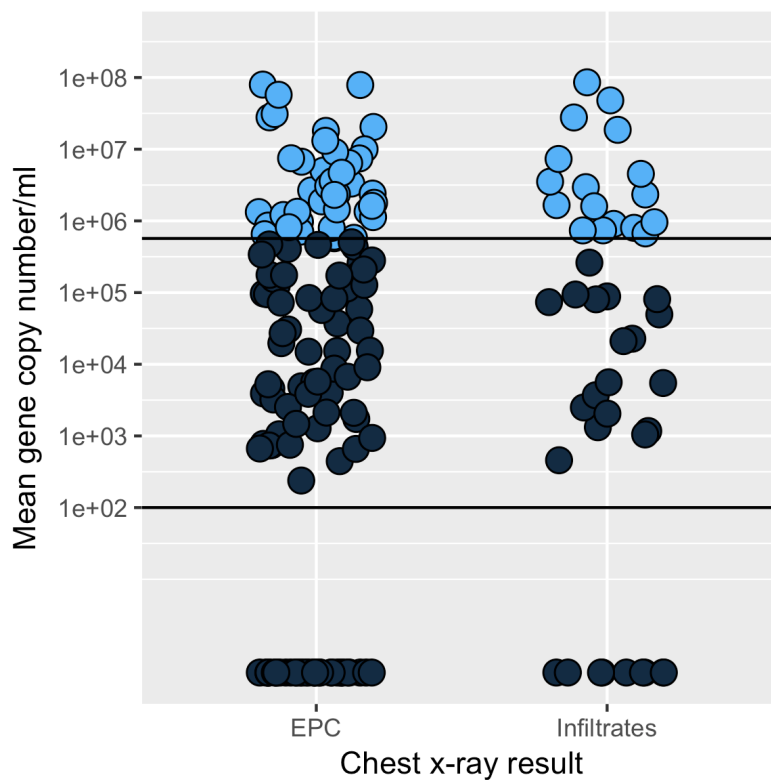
Detection of pneumococcal pneumonia in Nepalese children admitted to hospital with abnormal chest x-rays using a *lytA* copy number threshold of 569,000.
